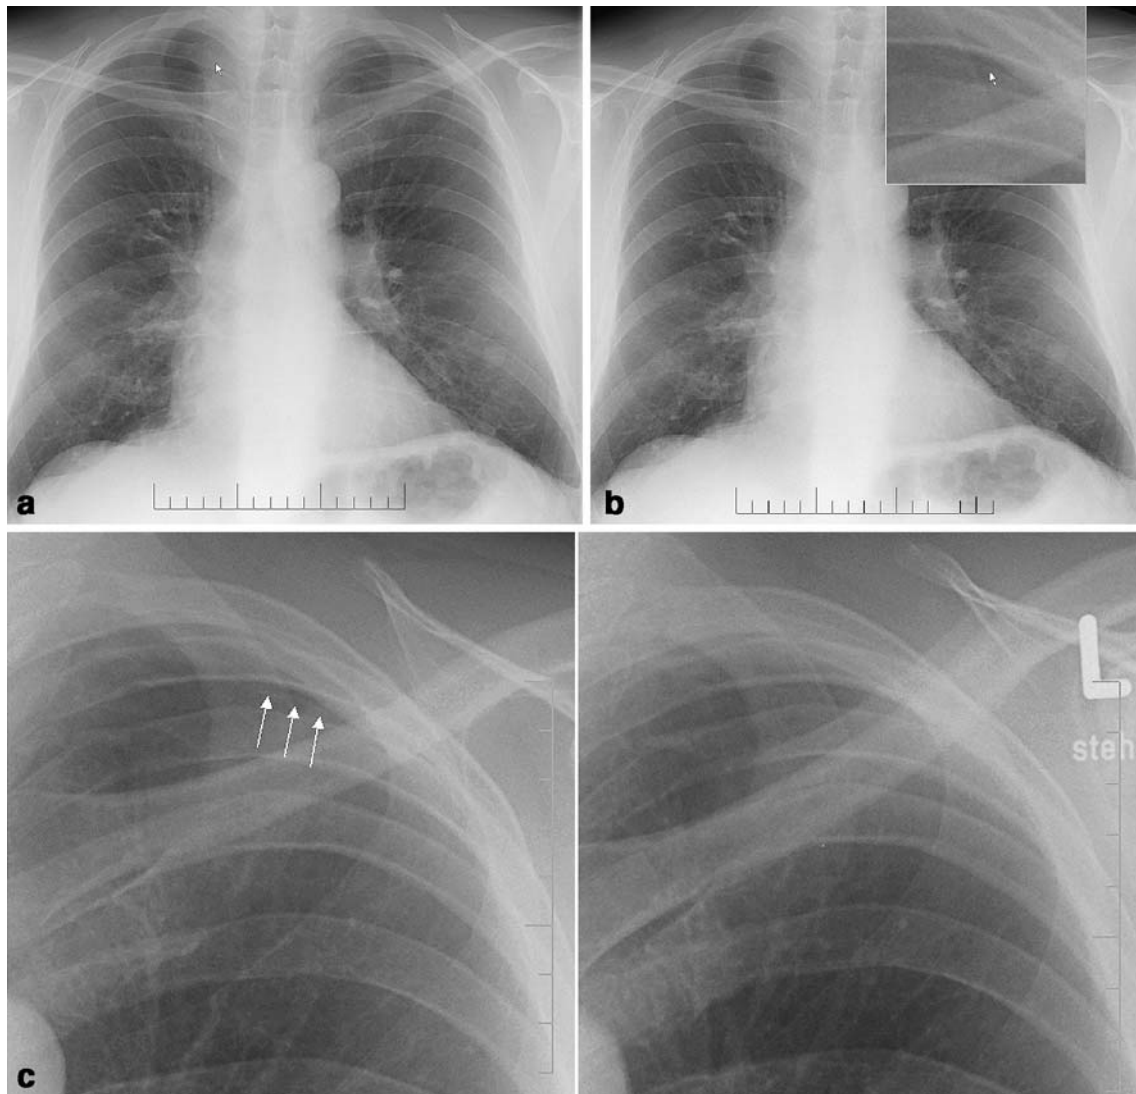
A 62-year-old man with pneumothorax adjacent to the left lung apex. The very decent line of pleural margin can be hardly identified on the 1K-matrix soft-copy image (a) but is clearly depicted with the 3K-matrix zoom function focusing on the lung apex (b; *small white arrow*). Follow-up chest X-ray 1 week later
